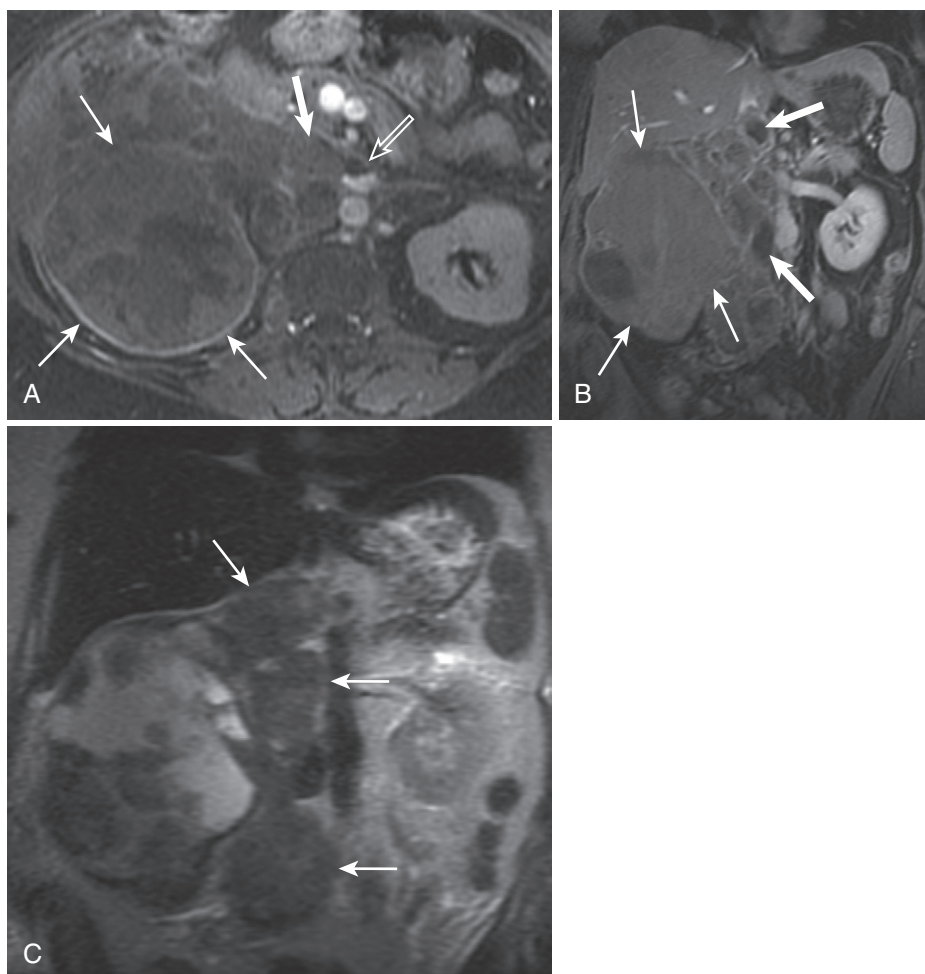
RCC with tumor and bland thrombus. A, A large complex mass replacing the right kidney (*thin arrows*) on the postcontrast image is associated with enhancing tumor thrombus in the IVC (*thick arrow*) and bland thrombus extending into the left renal vein (*open arrow*). B, The coronal enhanced image shows the large right renal mass (*thin arrows*) with bland thrombus superior and inferior to the renal vein (*thick arrows*). C, The coronal T2-weighted image catalogs the extent of retroperitoneal lymphadenopathy in the right paracaval region (*arrows*).
